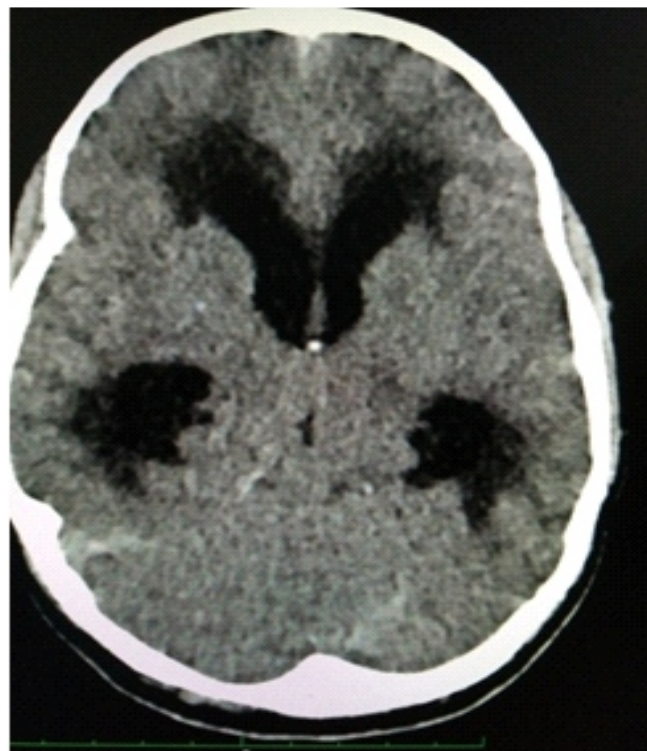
CT head showing dilated lateral ventricles with hyperdense mass(NCC) at foramen of monro
